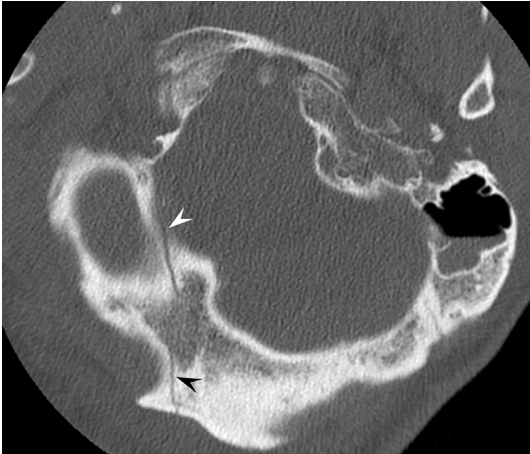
Type 1 occipital bone fracture. Axial CT demonstrates a fracture line (*arrowheads*) through the lateral aspect of the condyle, where it does not affect the alar ligament or tectorial membrane.
